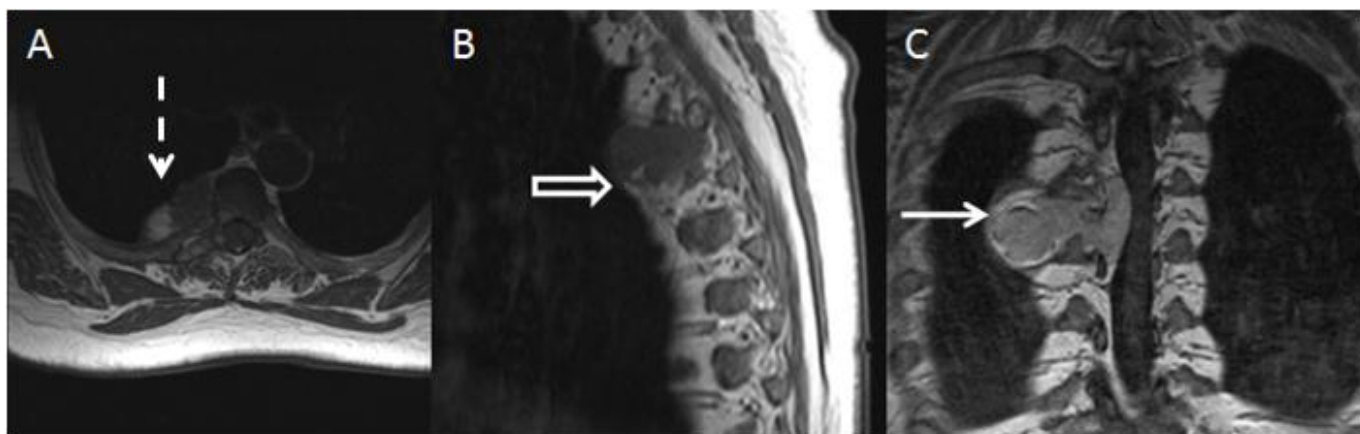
MR appearances of an angioliipoma in a 71 year old female. 5A) Axial image from T1-weighted spin echo sequences (TR 591, TE 17, 4mm slice thickness, FoV 512 x 512) demonstrating a focus of high signal intensity consistent with fat (dotted white arrow). 5B) Sagittal image from T1-weighted turbo spin echo sequences (TR 655, TE 13, 3mm slice thickness, FoV 512 x 512) revealing a rim of hyperintensity around the isointense lesion, in keeping with a fatty capsule (open white arrow). 5C) Coronal image from post-gadolinium T1-weighted spin echo sequences (TR 359, TE 15, 3mm slice thickness, FoV 320 x 240, 15ml Dotarem 15ml contrast medium) demonstrating avid enhancement and a curvilinear region of signal void (white arrow) consistent with chemical shift artefact.
